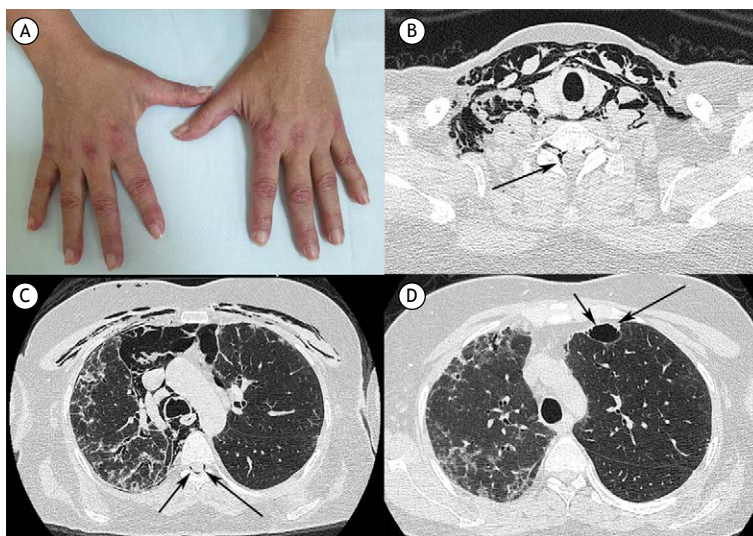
Forty-five-year-old woman with dermatomyositis. (A) Gottron's papules were seen on the hands due to dermatomyositis. (B, C) Axial CT images at admission showed extensive subcutaneous emphysema in the neck and chest wall, pneumomediastinum, right pneumothorax, and pneumorrhachis (black arrows). (D) Axial CT image nine months earlier showed a subpleural bleb in the left upper lobe (black arrows) and interstitial lung disease, which was more pronounced in the right lung.
